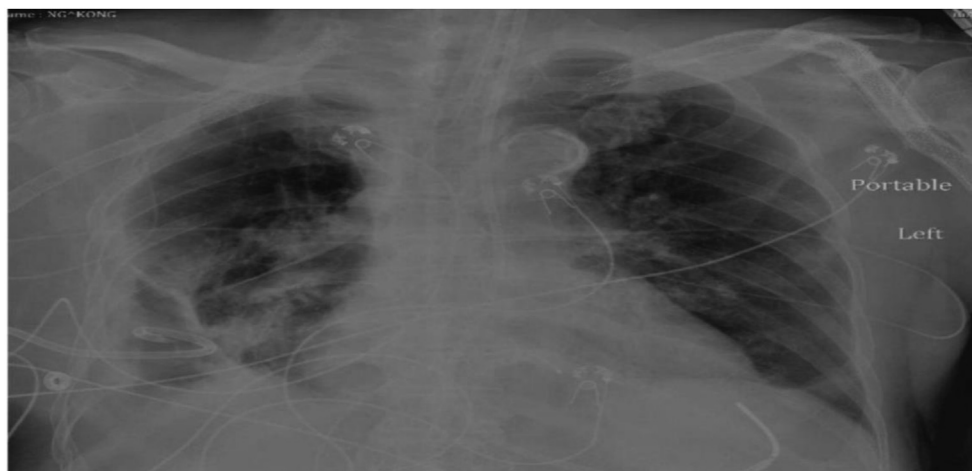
Chest X-ray featuring opacification of the peripheral aspect of the right hemithorax, most pronounced in the right middle of the lung.
